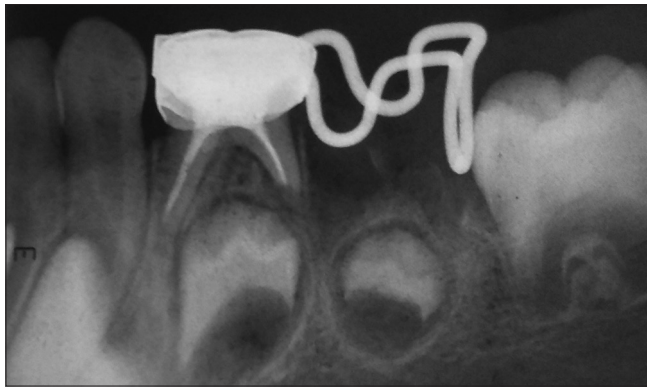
Radiograph immediately after cementation of the modified distal shoe space maintainer.
